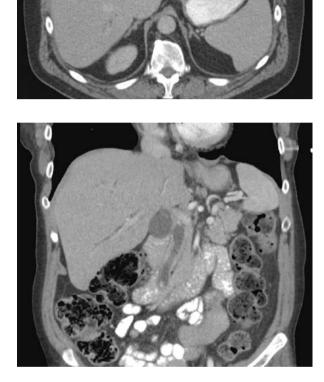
Coronal CT showing a CBD dilated to 13 mm (center, dark gray), with a calcified distal CBDS
